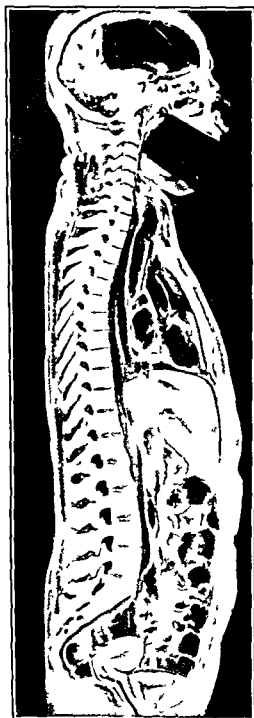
Radiograph of a sectioned calaver that demonstrates from the lateral aspect the anatomy and primary curves of the vertebral column. (Reproduced through the courtesy of H. O. Mahoney, B. J. Anson, and R. I. D. at Department of Anatomy, Northwestern University Medical School, Chicago, Ill., and Radiography and Clinical Photography, with personal permission of Professor Anson.)
